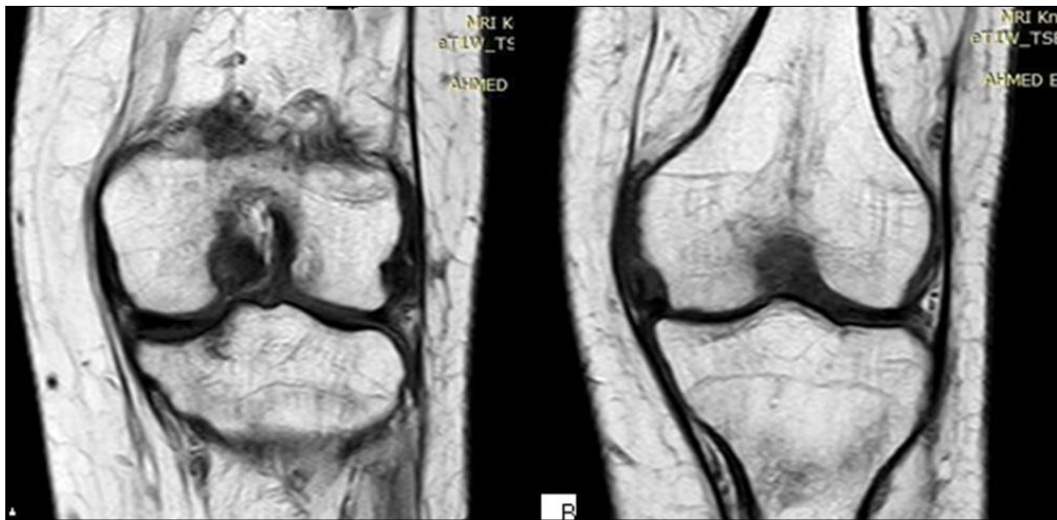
A: Coronal T1W knee MR image demonstrating Medial Collateral Ligament sprain. The Medial Collateral Ligament is seen encased by fluid signal denoting its sprain. B: Coronal T1W knee MR image demonstrating anterior cruciate ligament partial tear. We see fluid collection within and around it
